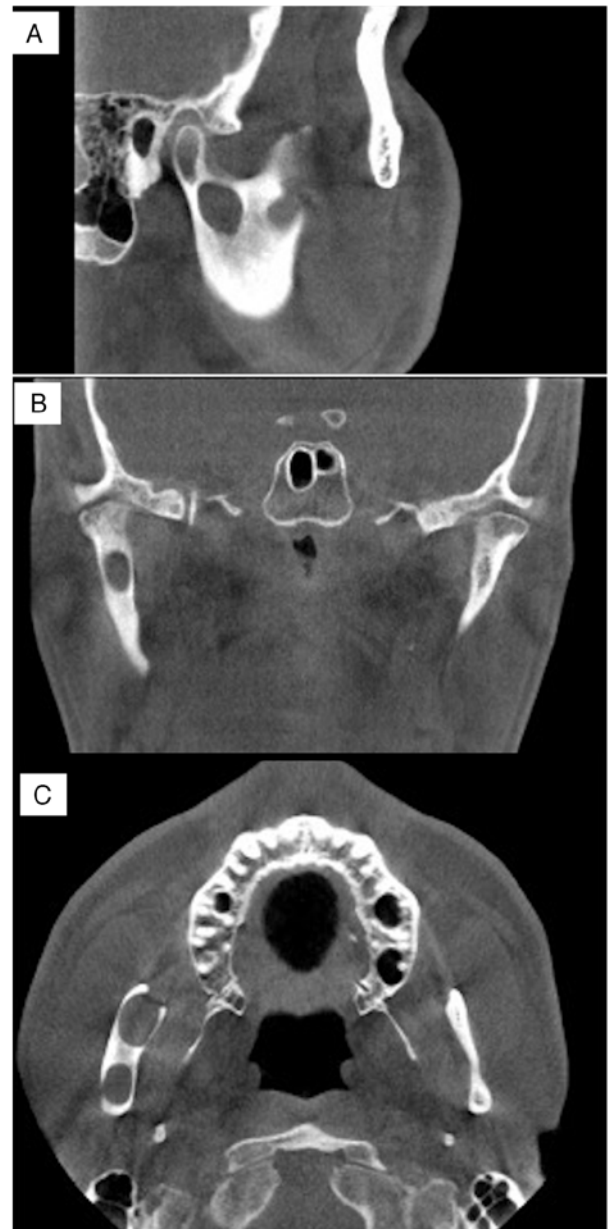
Cone-beam computed tomography images. (A) Sagittal, (B) coronal and (C) horizontal views of a cyst-like transmission image measuring 13x12x6 mm in the base of the condyle. A suspected residual cyst was detected on the anterior margin of the right mandibular ramus. The cysts were not connected.
